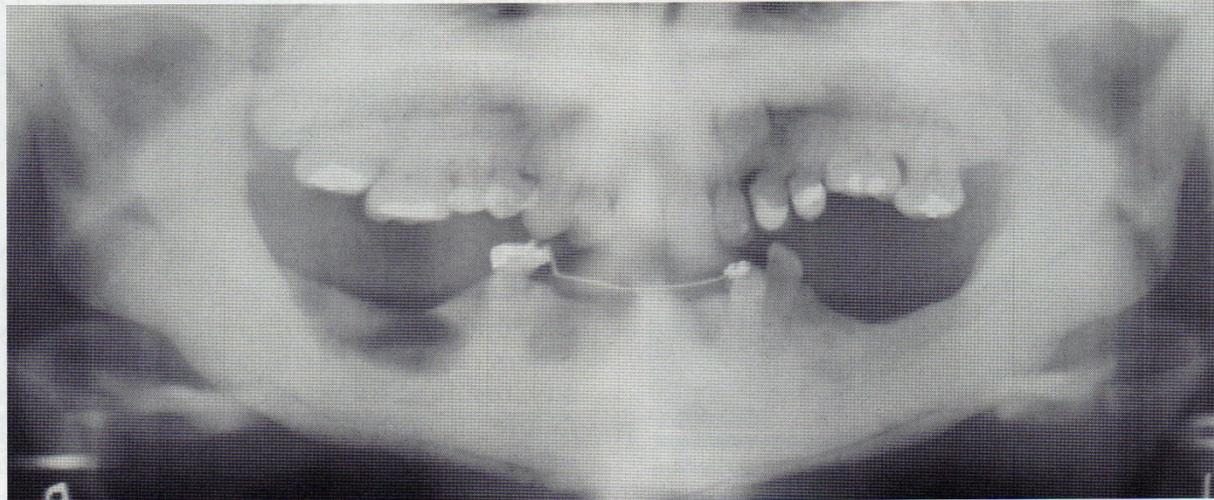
Osteopetrosis: radiograph of the same patient as in the previous pictures showing the line of separation of the sequestering
